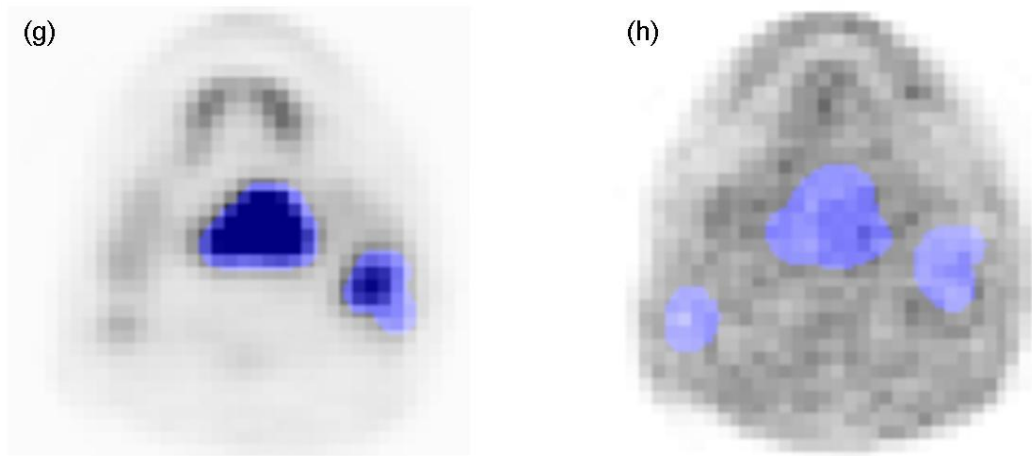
FMISO signal superimposed to the GTV structures, contoured from the FDG signal at the planning moment (g) and after a week (h). See Deliverable report D.JRA 3.5 for details.
